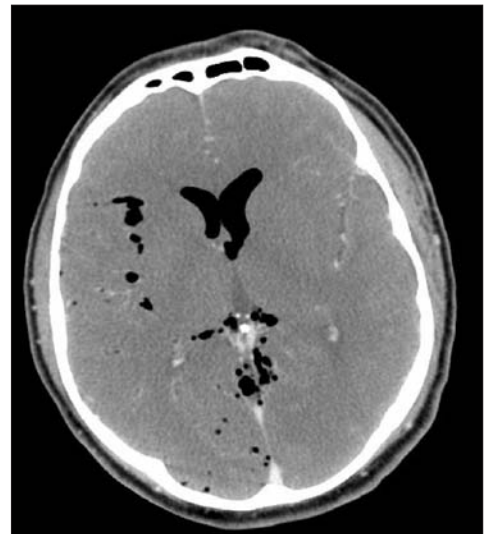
Computed tomographic scan of the head of a 32-year-old man showing pneumocephalus.
